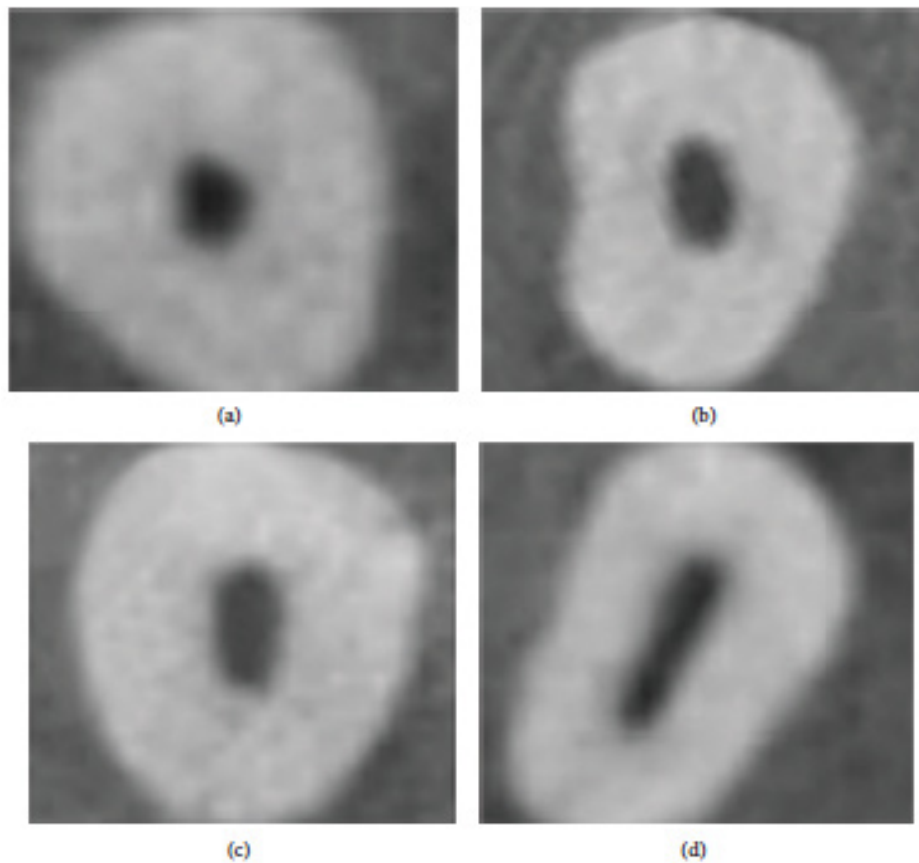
Cross sections of cone beam computed tomography scans showing various shapes of the access cavity at cemento-enamel junction [15]; (a) round, (b) oval, (c) long oval, and (d) flattened.
